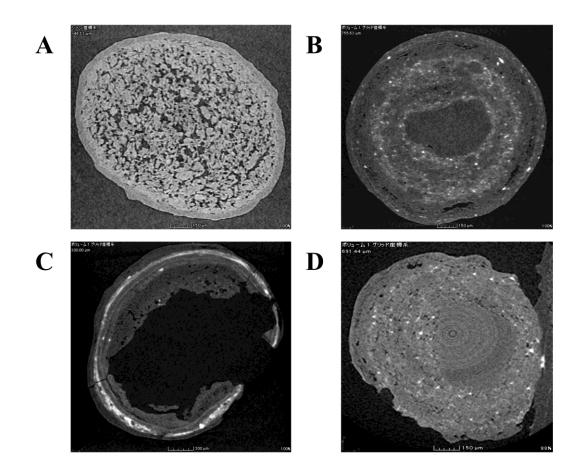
X-Ray CT images of granules found in sample A-078 collected in Myanmar in 2014. A) Standard sample; B) regular granule with apparently intact coating (white granule 1); C) irregular granule with hole (white granule 2); and D) yellow granule with incomplete coating
